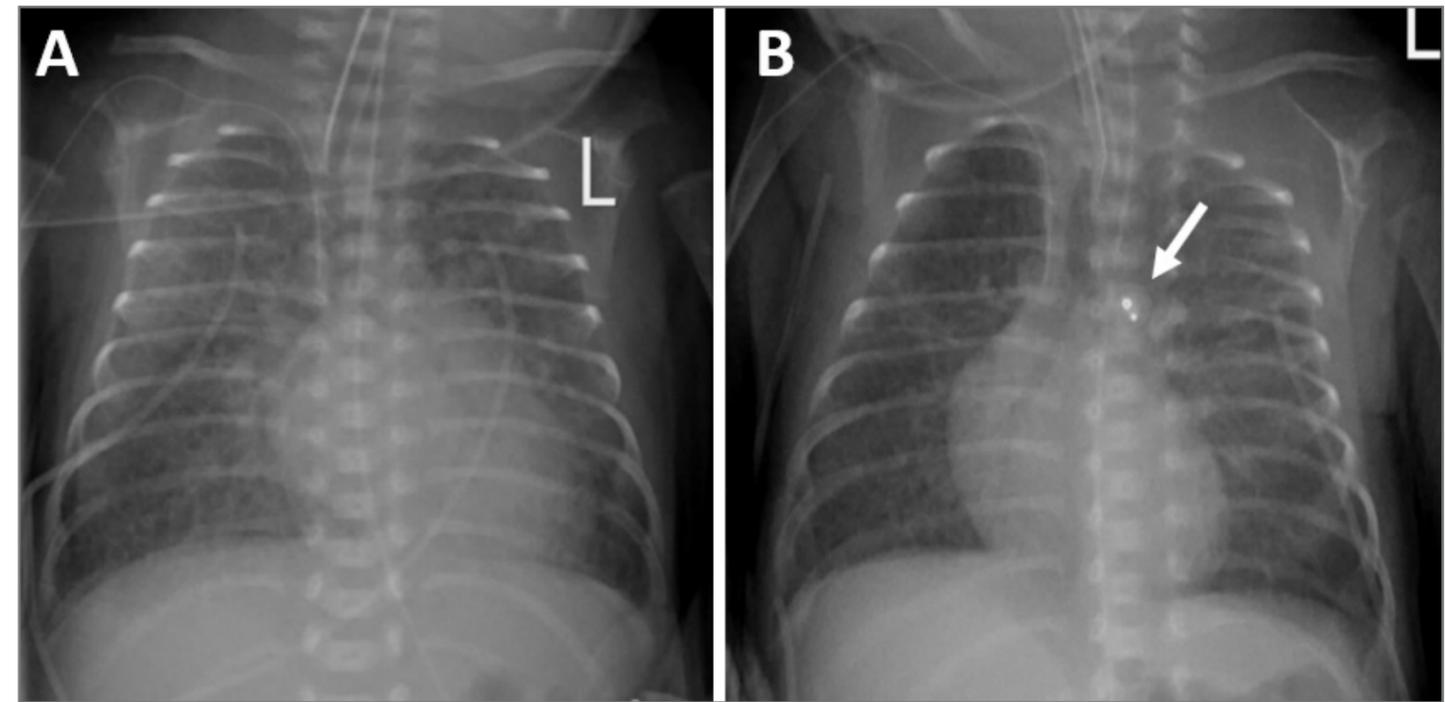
AP chest X-ray images. (A) Prior to the procedure there is diffuse lung granularity with coarse parenchymal infiltrates and mild cardiomegaly, changes consistent with significant premature lung disease and pulmonary overcirculation. (B) Within days following the procedure, there is stable diffuse granularity with improved pulmonary edema. The cardiac silhouette is no longer enlarged. The ductal device is seen in its expected position (arrow).
